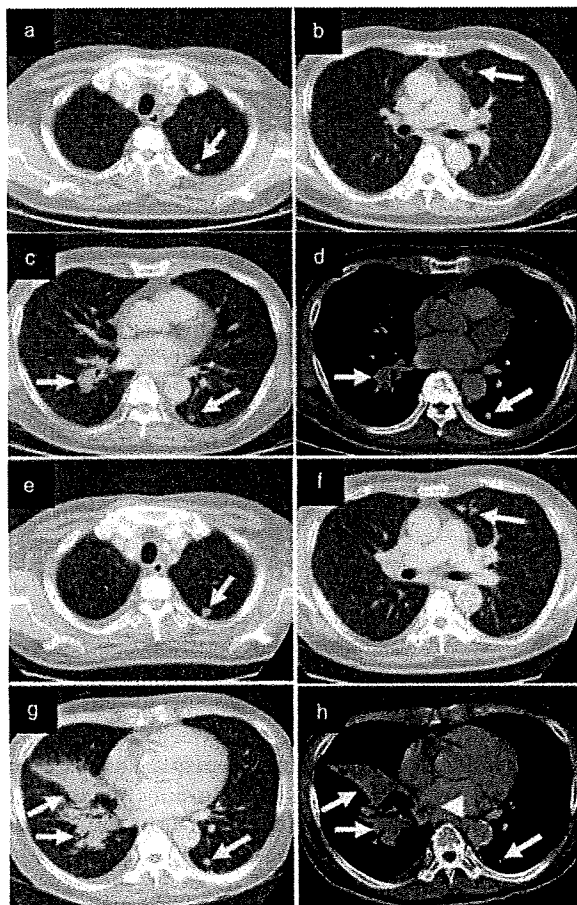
(a-d) Chest computed tomography showed deterioration of pulmonary metastases after three courses of systemic combination chemotherapy of tegafur-uracil and interferon- α (arrows). (e-h) Chest computed tomography showed further deterioration of pulmonary metastases after five courses of systemic combination chemotherapy of 5-fluorouracil and cisplatin (arrows). (h) Pulmonary metastases in the right lung infiltrated the right pulmonary artery (arrowhead).
